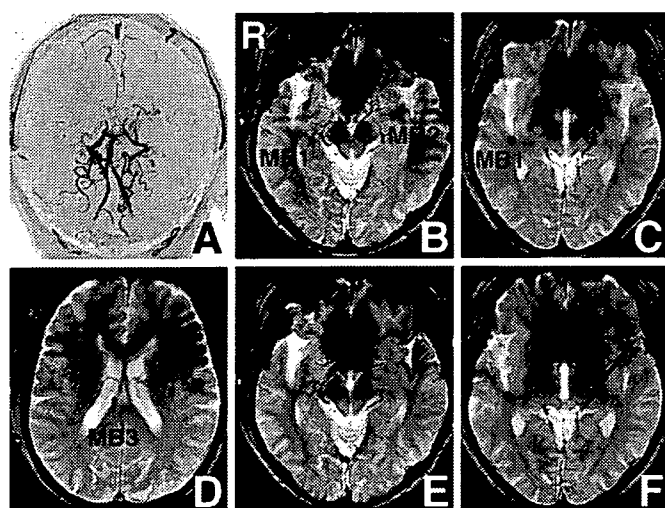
A: Magnetic resonance (MR) angiogram in November 2003 demonstrating typical angiographic findings of moyamoya disease. B-D: T_2^* -weighted MR images showing three asymptomatic microbleeds in the right temporal operculum (MB1), the left insula (MB2, arrowhead), and the right corpus callosum (MB3). E, F: Follow-up T_2^* -weighted MR images in November 2004 revealing asymptomatic subarachnoid hemorrhage in the left sylvian cistern (arrow), which seemed to be derived from MB2 in the left insula.
